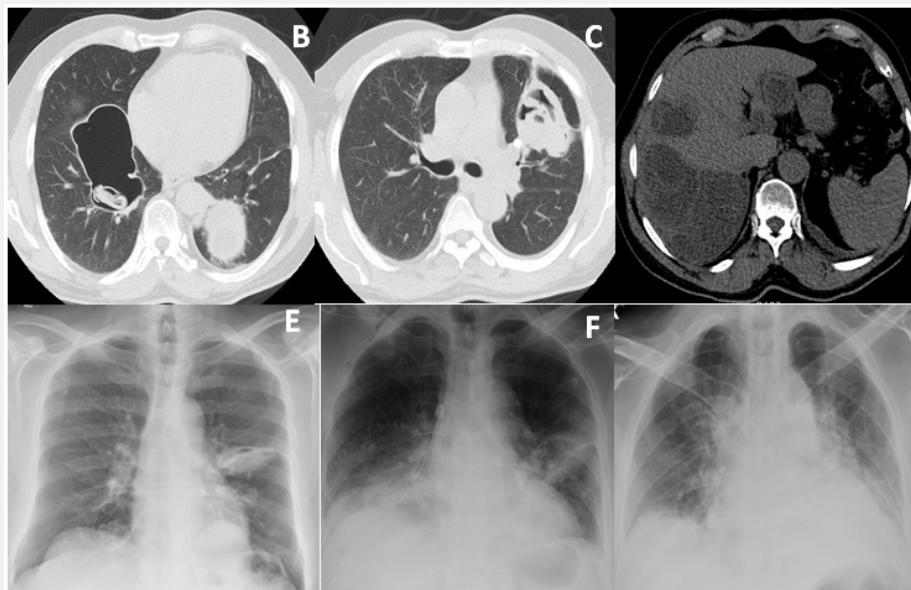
(A) CT Scan of Thorax showing a large cystic lesion in the Right lung. (B) CT Scan of Thorax showing a large cystic lesion in the Left lung. (C) CT Scan of Liver shows multiple cystic lesions. (D) Pre-operative chest x-ray. (E) Chest X-ray after right cyst excision. (F) Chest X-ray after bilateral staged thoracotomy.
